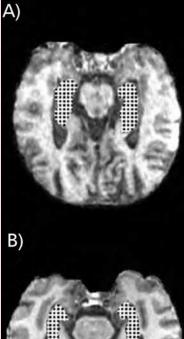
Magnetic resonance images (MRI) of (A) a normal brain and (B) a brain showing atrophy in the hippocampal area from an Alzheimer's disease patient. Courtesy of Dr M. de Leon, New York University School of Medicine, USA.
